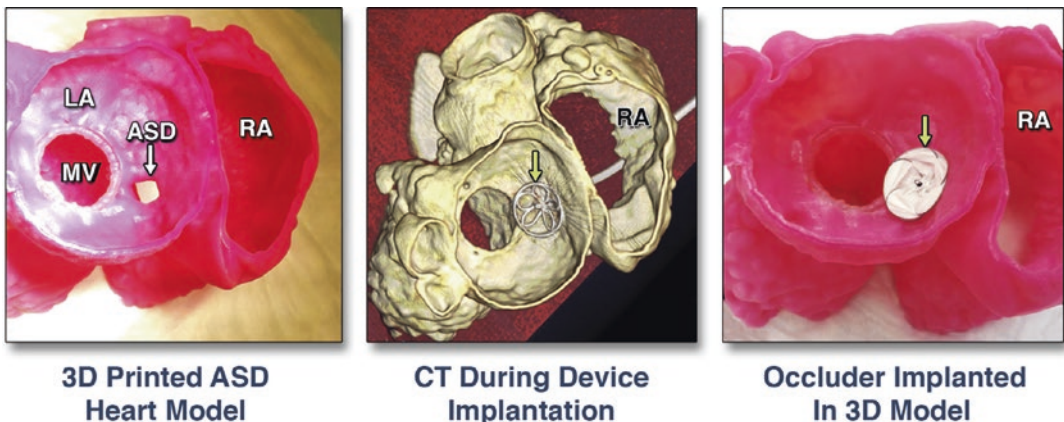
3D-printed model of an atrial septal defect (ASD) imaged by CT (left). 3D-printed model with bench-top implanted septal occluder device (yellow arrows) (middle). CT scan of septal occluder implantation within the 3D-printed model. *LA* left atrium, *MV* mitral
